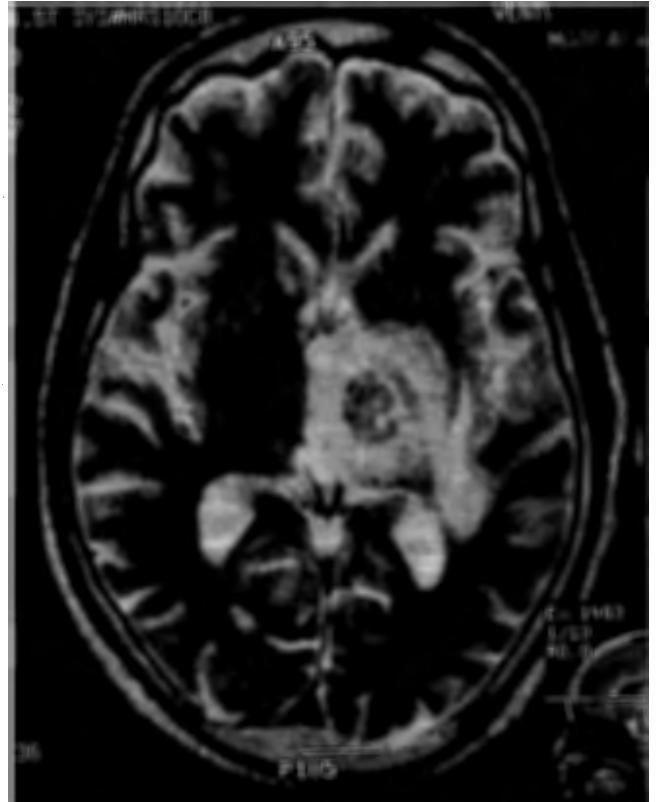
T2 MRI picture of the same area showing central hypodensity and surrounding high signal.
